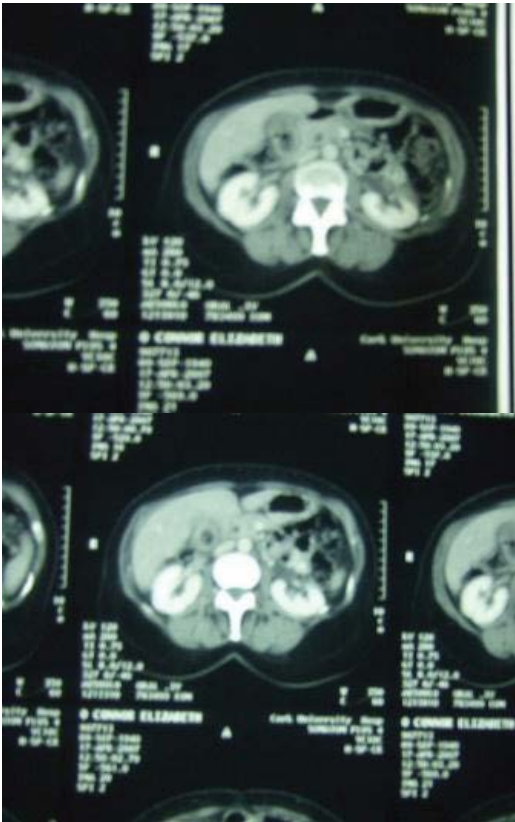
CT-Scan after six weeks..
